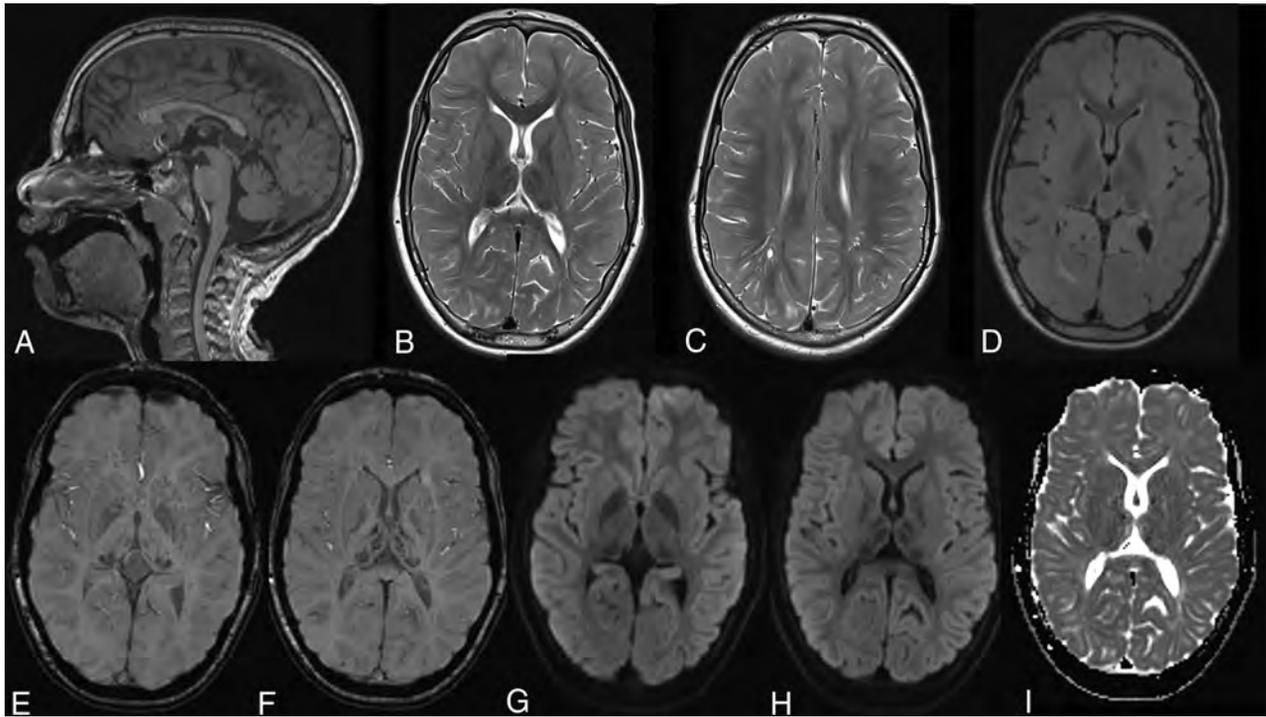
Typical MR imaging findings in an 11-year-old girl with AGU. *A*, Sagittal T1WI shows a relatively thin corpus callosum and a pineal cyst. *B*, Axial T2WI with typical hypointensity in the thalami and especially in the pulvinar nuclei. *C*, Axial T2WI shows hyperintensity in the white matter, poor differentiation between gray and white matter especially in frontal lobe, and some mildly dilated perivascular spaces. *D*, Axial FLAIR image also shows the hypointensity in the pulvinar nuclei and hyperintensity in the white matter. *E* and *F*, Axial SWI with hypointensity in the pulvinar and medial and anterior nuclei in the thalami. *G–I*, Axial DWI and ADC images show no signs of restricted diffusion.
